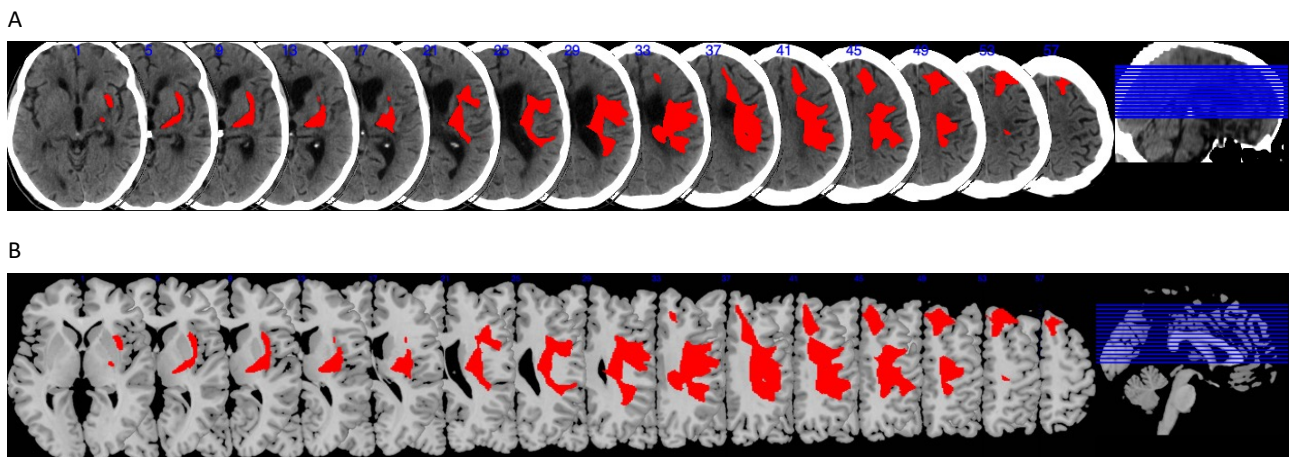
Patient's lesion at one year from stroke onset. Panel A display patient's CT scan and the reconstructed lesion normalized to an age-appropriate template brain. Panel B displays a Montreal Neurological Institute template and the patient's reconstructed lesion superimposed onto it, highlighting the precise anatomical location and extent of the lesion within standardized brain coordinates.
